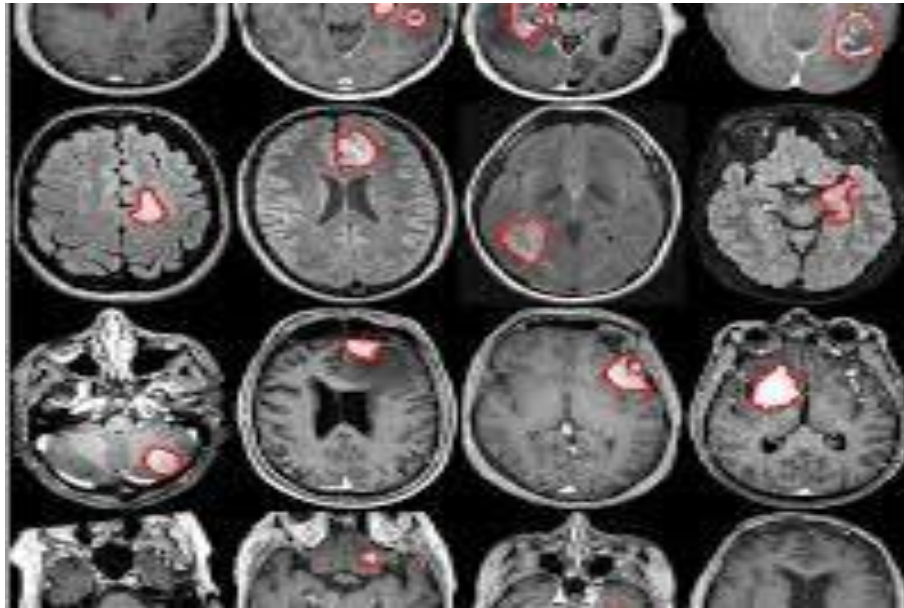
Brain Tumor in an MRI Scan
